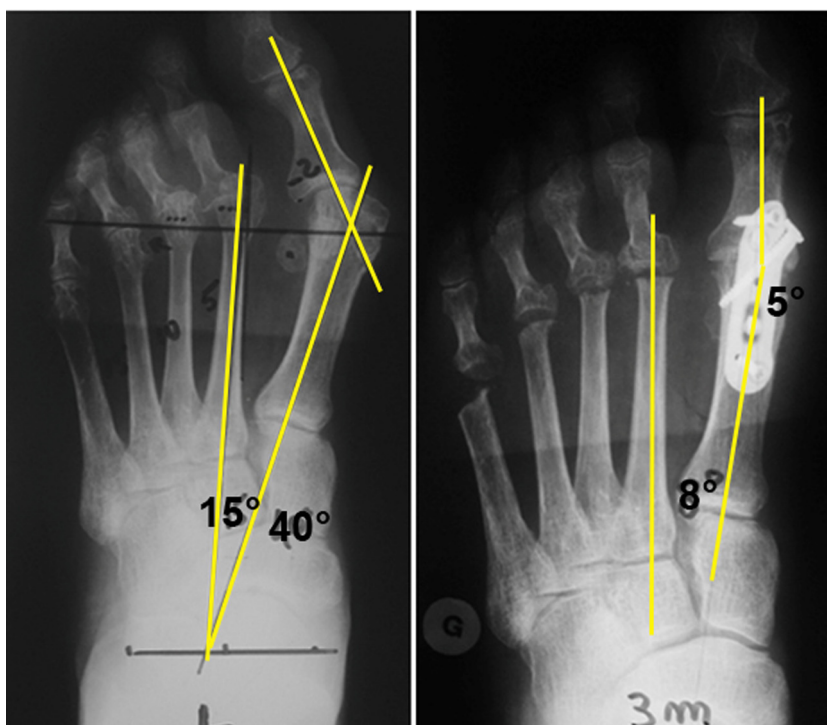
MTP-1 arthrodesis with resection of the metatarsal heads in a female patient with rheumatoid arthritis: preoperative AP dorsal-plantar X-ray with load (left, M1P1 40°, M1M2 15°) and at 3 months postoperative (right, M1P1 5°, M1M2 8°).
